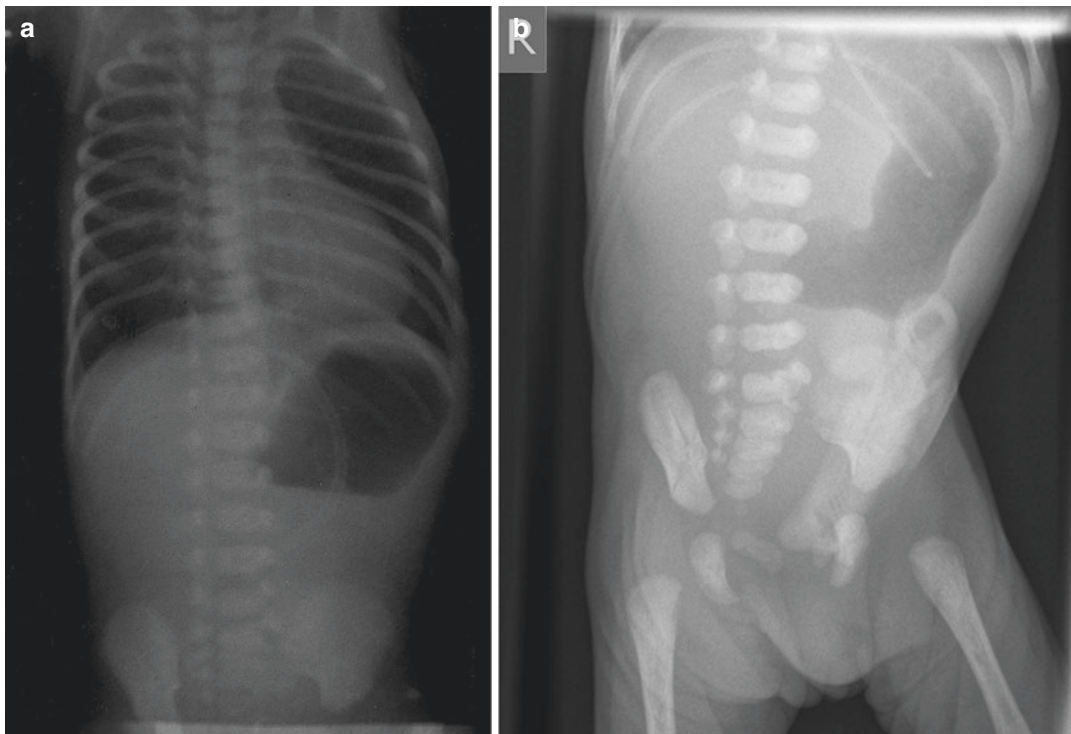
Plain abdominal radiographs showing distended gastric bubble in pyloric atresia
